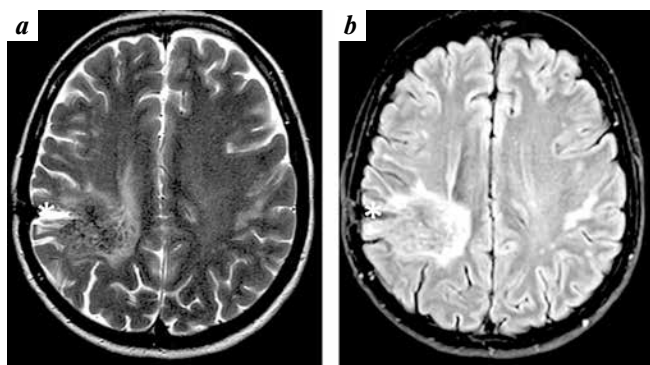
Clinical case 1. Brain magnetic resonance imaging of patient performed 8 months after the biopsy: the biopsy area is marked with a star. The increase of the volume of lesion and postoperative changes on T2 (a) and FLAIR (b) sequences is not determined
